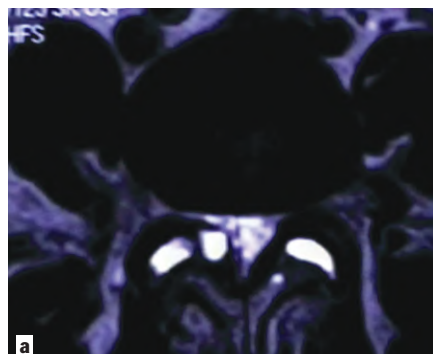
This MRI clearly demonstrates a juxta-articular cyst compressing the thecal sac. These cysts can be decompressed endoscopically if large enough to be visualized and accessible by foraminoplasty.
